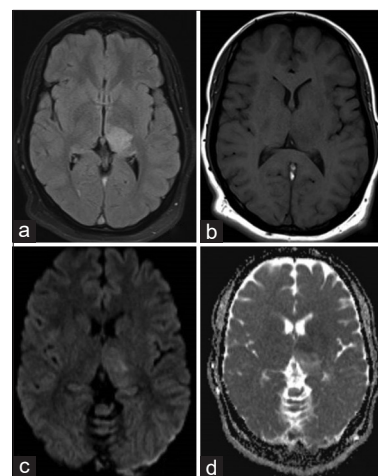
Magnetic resonance imaging sequences of the patient in Case 2. Magnetic resonance imaging T2 Fluid-attenuated inversion recovery hyperintensity over left dorsomedial thalamus (a). Corresponding faint T1 hypointensity (b). Diffusion-weighted images and apparent diffusion coefficient sequences (c and d) showing faint diffusion restriction of the thalamic hyperintensity
